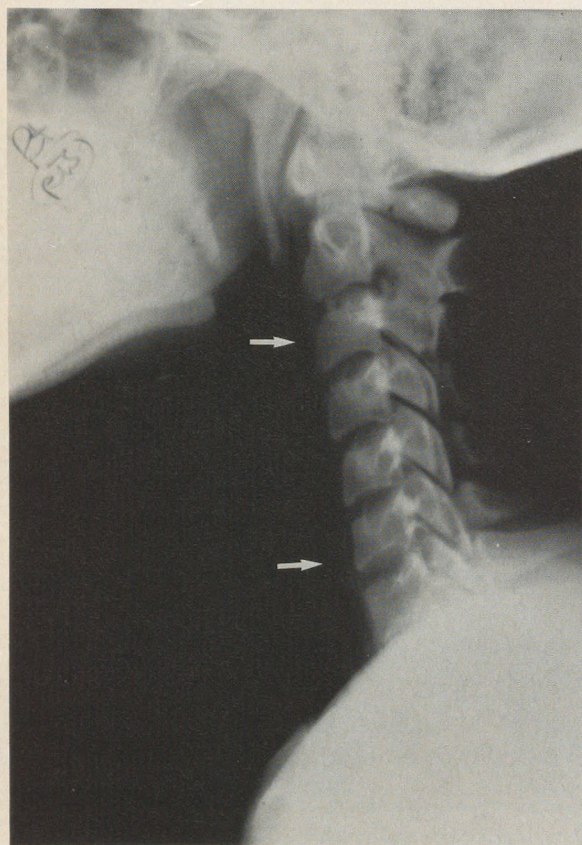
Lateral soft-tissue x-ray film of the neck showing free air in the retropharynx (arrows).
